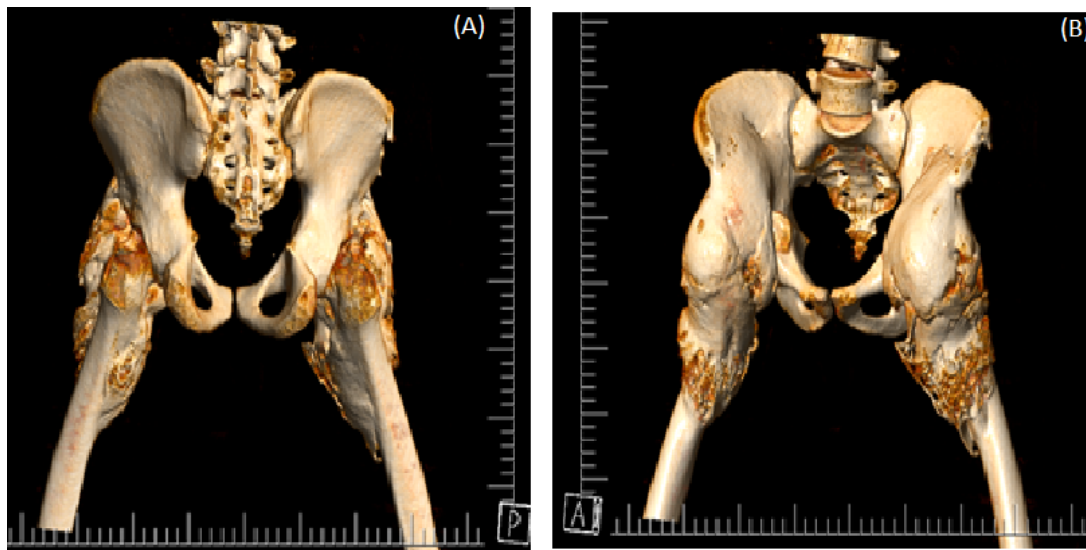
3D CT reconstruction of the pelvis.
